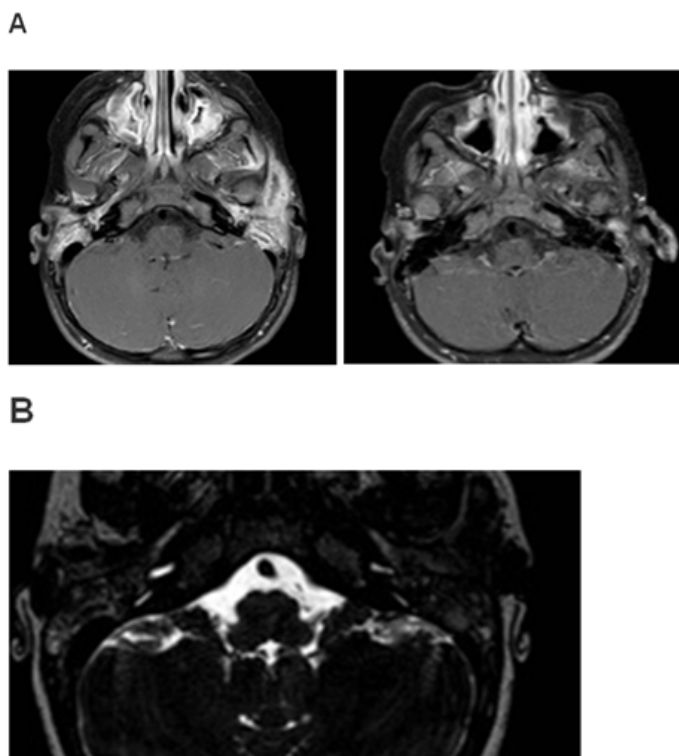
Magnetic resonance imaging (MRI). A. T1 sequence. Contrast enhancement in the tympanic cavity and a soft-tissue mass in the mastoid-petrous-squamous area of the temporal bone. B. T2 sequence. Hyperintensity of the cochlea is partially absent.
